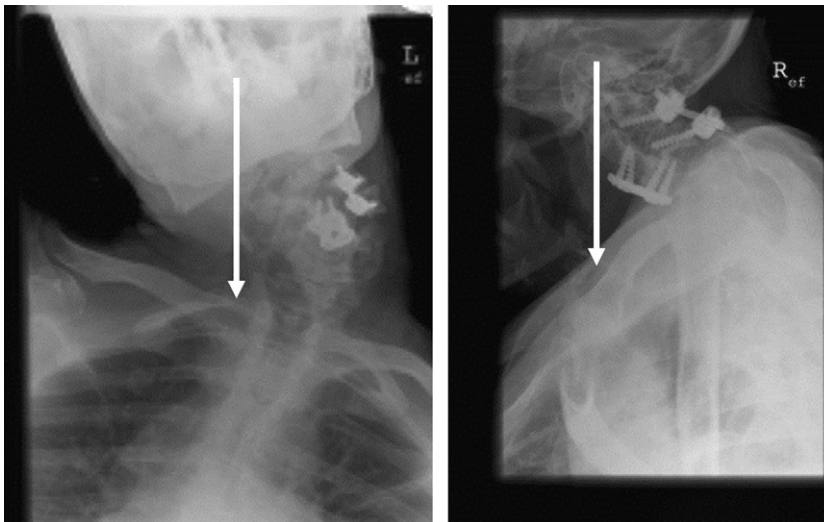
(Left) Anterior-posterior radiograph showing coronal malalignment. (Right) Lateral radiograph showing sagittal malalignment.
